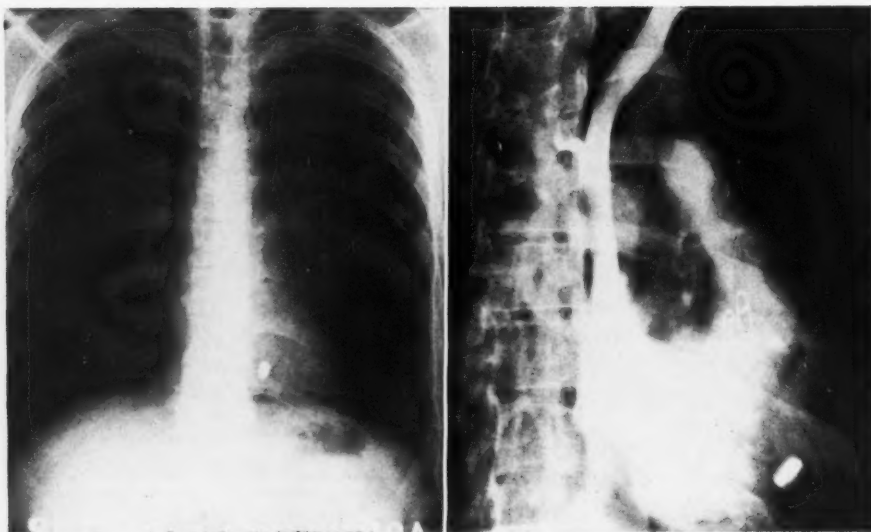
Left*. PA roentgenogram of the chest of a 27-year-old man who incurred a ricochet shell fragment wound of the right posterior lower thorax, demonstrating the missile in the myocardium; the exact location was not determined. Patient was asymptomatic. *Right*. Venous angiogram performed by Dr. George P. Robb with right anterior oblique projection, demonstrating that the retained shell fragment was not in the right ventricle but probably in the interventricular septum. Subsequent angiocardigraphic study confirmed this impression. Wire sutures are result of exploratory thoracotomy.
